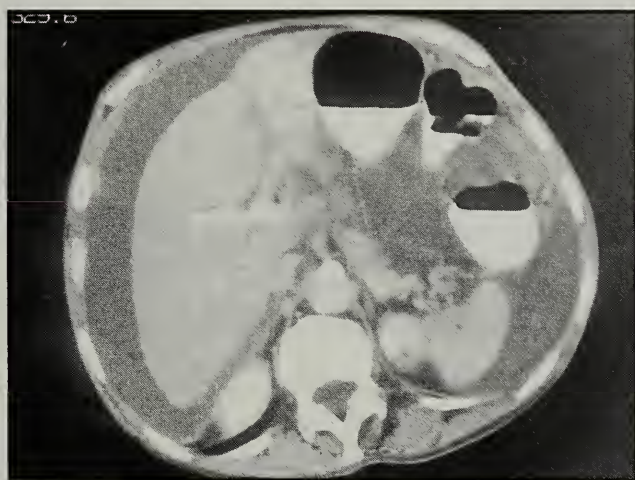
CT scan of the abdomen.
